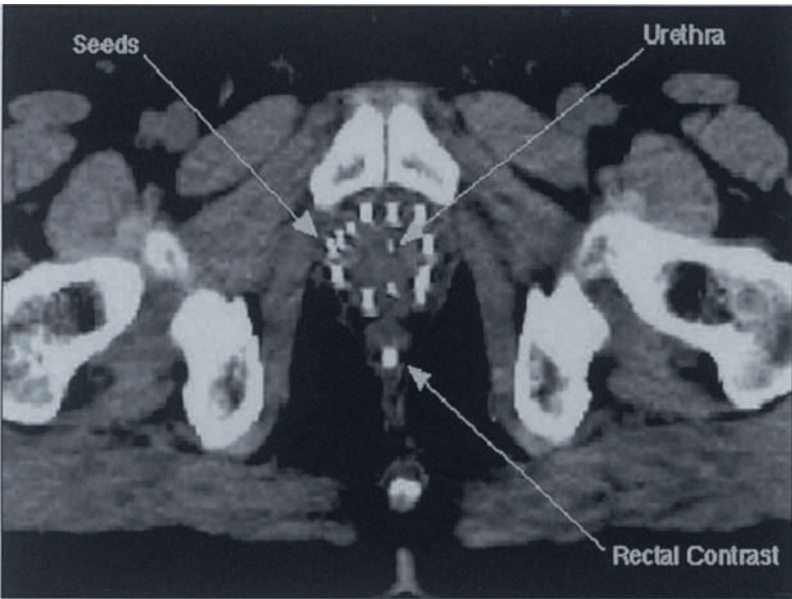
Postimplant evaluation. It is essential to evaluate the degree to which the actual implant matches the preimplant plan, both for purposes of identifying seriously suboptimal implants as well as to provide feedback to the clinician that will allow technical improvements. Postimplant evaluation is best achieved by CT imaging. The same planning software that is used for initial planning of an implant can generally be used for the postimplant analysis. Each seed position is digitized, isodose curves are generated, and the coverage of the prostate at different dose levels is assessed. Attempts have been made to correlate postimplant dosimetry with subsequent clinical outcome and indicate that, for ^{125}I , the 5-year biochemical control is excellent if at least 90% of the prostate volume receives at least 140 Gy [13].
